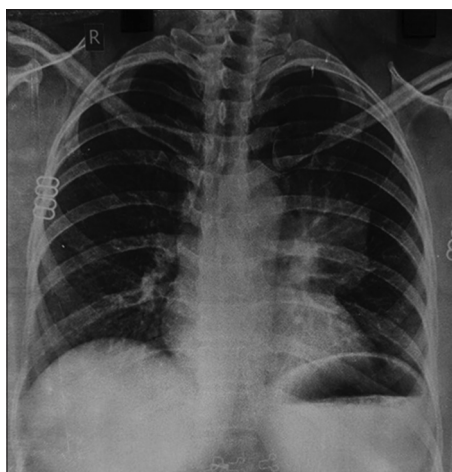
Chest X-ray showing mediastinal opacity with hilum overlay sign
